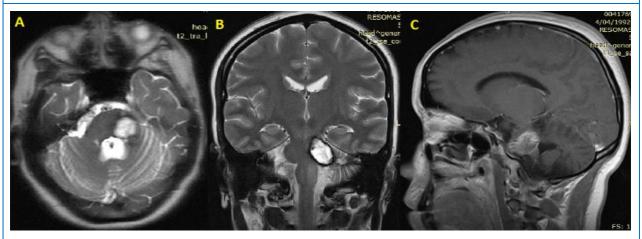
Brain magnetic resonance imaging (MRI) with contrast, 1 month before admission, showing rebleeding of a pons cavernoma in (A) axial view T2, (B) coronal view T2, (C) sagittal view T1 with contrast.
